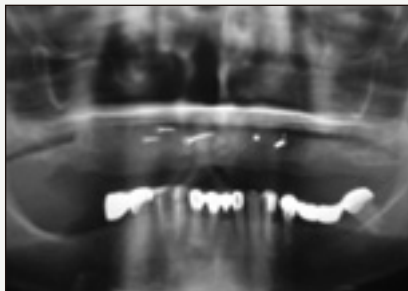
Panorex radiograph shows bone graft with fixation screws in anterior maxilla plus bilateral subantral vertical augmentations in posterior maxilla.
